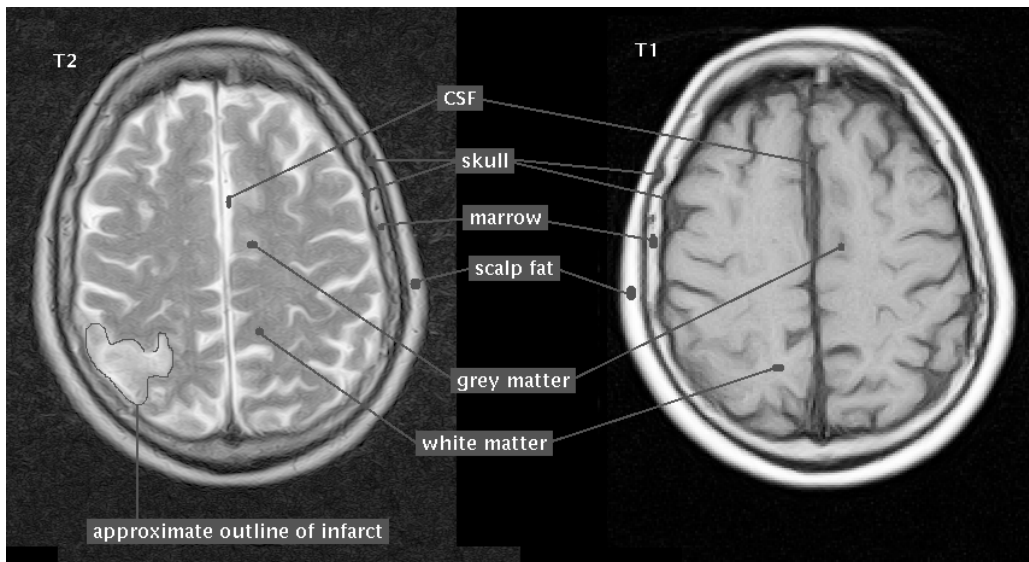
Two annotated sample MR images showing the same brain slice using different parameters. (This image is from the Project’s Web page.)
